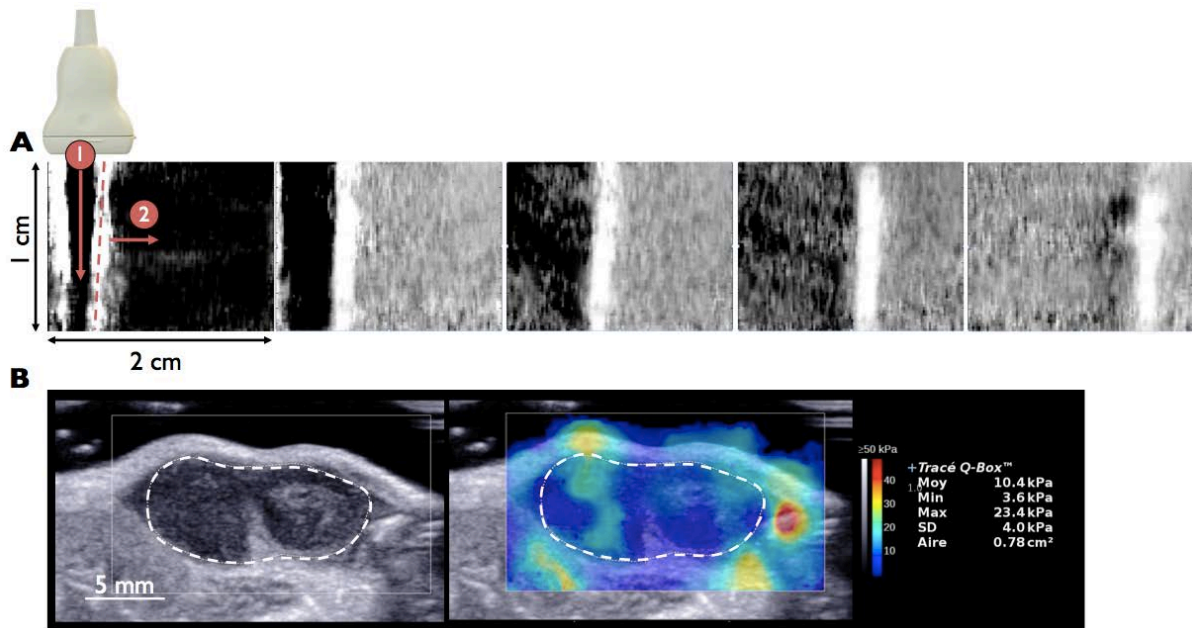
Shear wave propagation. A) A shear wave is generated by applying radiation force at different depths with focused ultrasound. The propagation of shear waves is monitored with longitudinal-wave imaging and shear-wave velocity is assessed at each point in the image to measure tissue stiffness. The red dashed line designates the shear wave front. B) The elastography color map of Lewis lung carcinoma (LLC) after 14 days of tumor growth, dashed line designates the tumor. Statistics of tumor stiffness (mean, max, min, SD and ROI area) are presented on the right of the imaging window.
